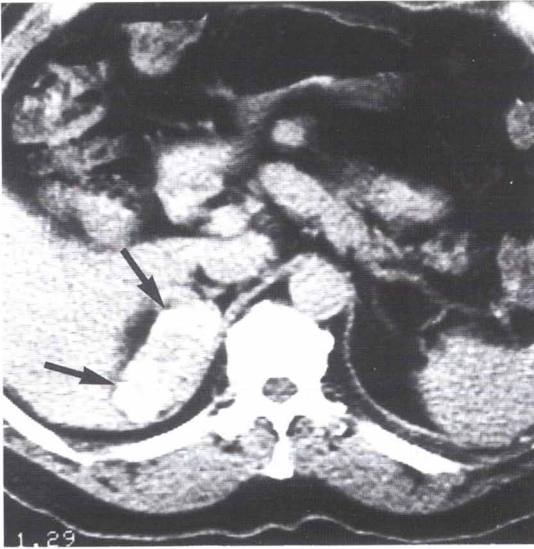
Postcontrast CT of the abdomen shows a highly-enhancing oval mass in the right adrenal gland (arrows).
